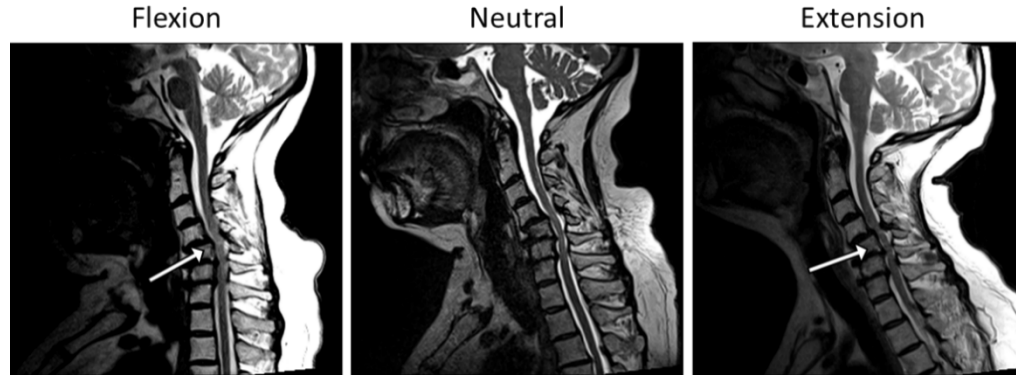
Flexion, neutral, and extension T2 weighted MRI of same patient from UIHC Department of Neurosurgery. Arrows indicate regions of increased spinal cord compression during movement.
